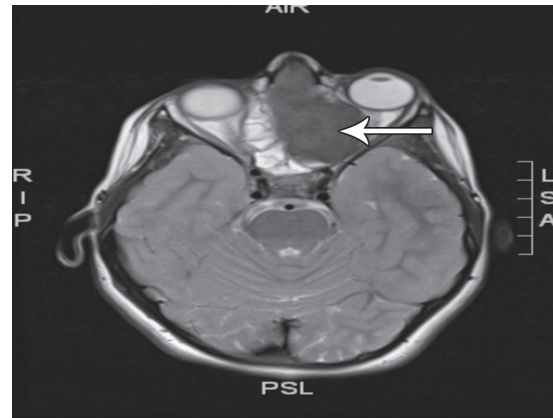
Axial T2 weighted MRI showing the mass encroaching on the left optic nerve.
